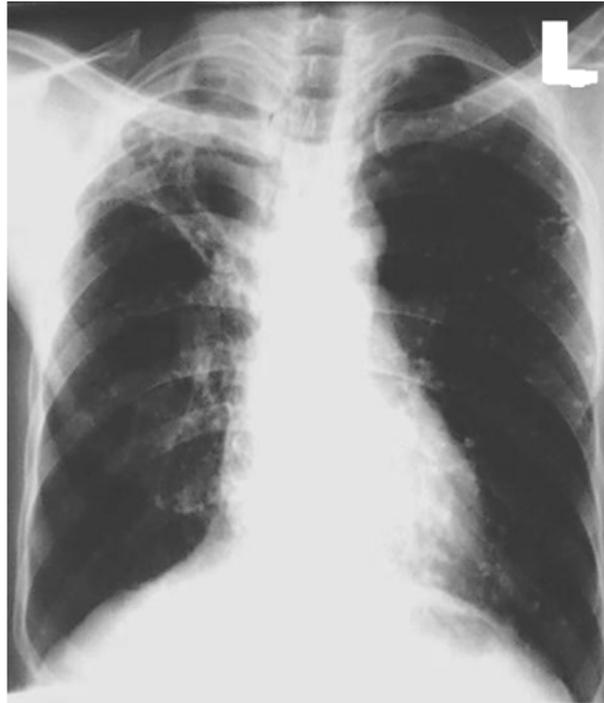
Repeat PA chest radiograph, taken on admission, showing less severe changes in the right upper zone with some resolution of the radiographic features when compared with the previous chest radiograph (Fig. 1). The left lung field showed pleural calcifications especially in the left upper and mid zones.
